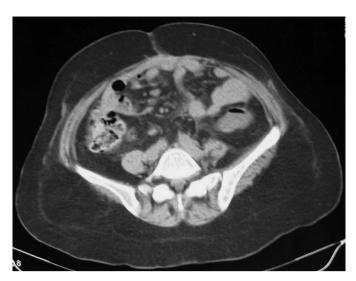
CT scan of the lower abdominal cavity demonstrating peritoneal carcinomatosis and extensive adhesions.
